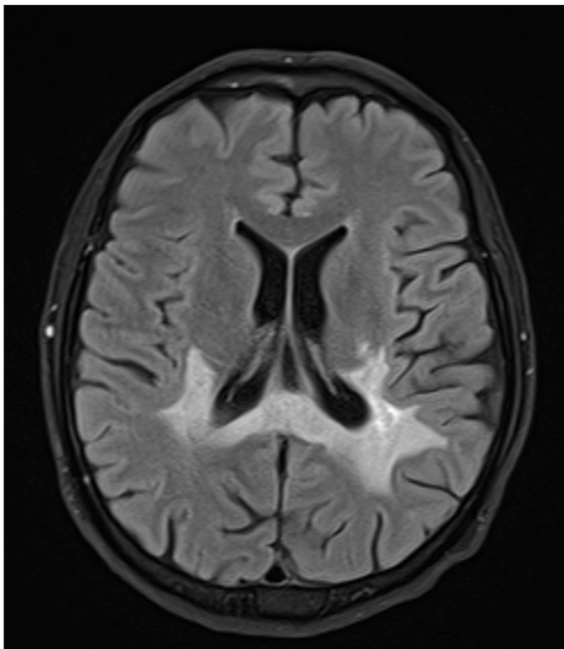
Patient 3 axial brain MRI T2/FLAIR sequence showing an extensive occipito-parietal hyperintensity, corresponding to a CALD form of X-ALD with demyelinating lesions.
